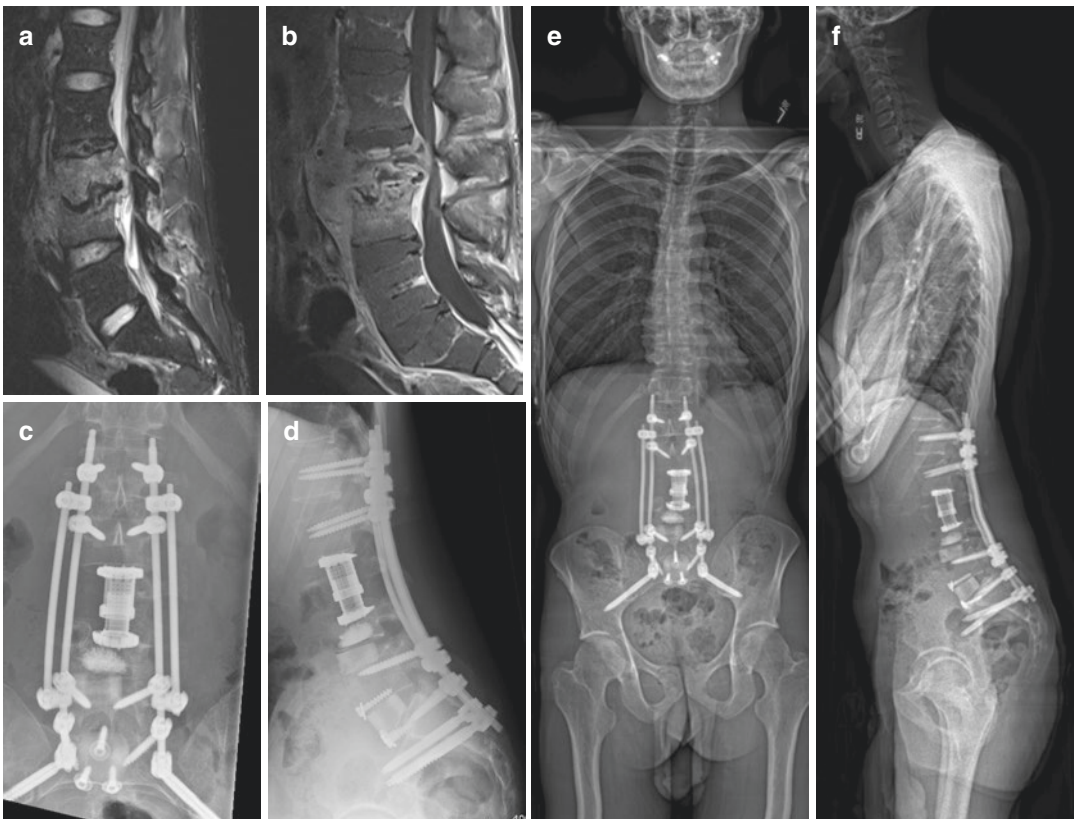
(a) T2 and (b) postcontrast sagittal MRI demonstrating extensive destruction by a disc-preserving infection, raising suspicion for tuberculosis (TB) vs fungus. The patient had a history of work in a warehouse in Arizona and eventually was discovered to have coccidioidomycosis.
